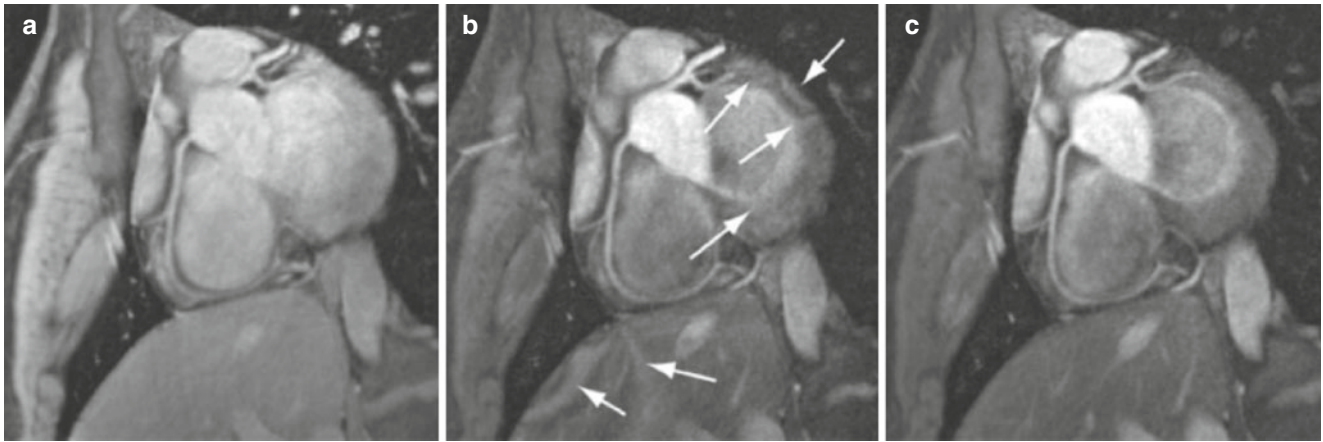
Reformatted 3D coronary MRI of the right coronary artery at 3T (a) acquired with no T_2 -Prep; (b) with T_2 -Prep; (c) with adiabatic T_2 -Prep. Arrows in (b) point to the artifacts resulting from T_2 -Prep
